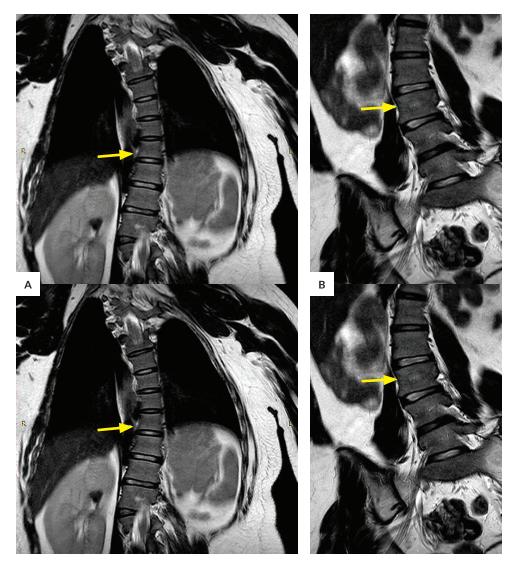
MRI of the spine showing (A) cervical and thoracolumbar dextroscoliosis and (B) thoracic levoscoliosis (yellow arrows).
